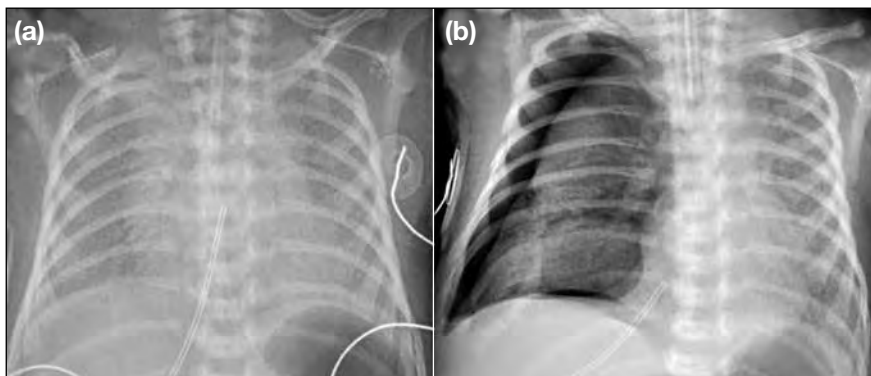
Pneumothorax complicating hyaline membrane disease. A 29+1 weeks preterm baby boy delivered by emergent Caesarean section for maternal antepartum haemorrhage. (a) Chest X-ray after birth showing bilateral small lung volume, diffuse symmetric infiltrates, air bronchogram, and absence of pleural effusion, typical of hyaline membrane disease. (b) Chest X-ray on day 3 after intubation showing right pneumothorax.
